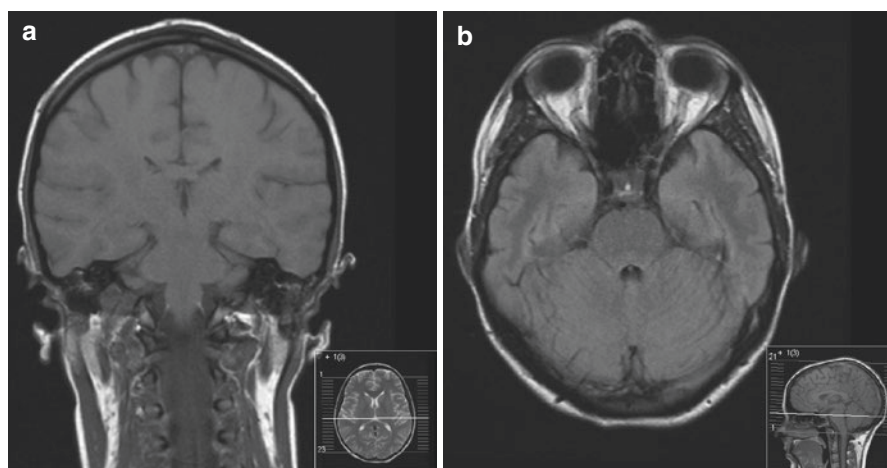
Coronal T1 weighted MRI (a) showing no flow within the superior sagittal sinus and (b) T2 weighted axial MRI showing patulousness of the optic nerve sheaths on both sides, but without an empty sella (implying that the pressure is raised but has only recently become so)
